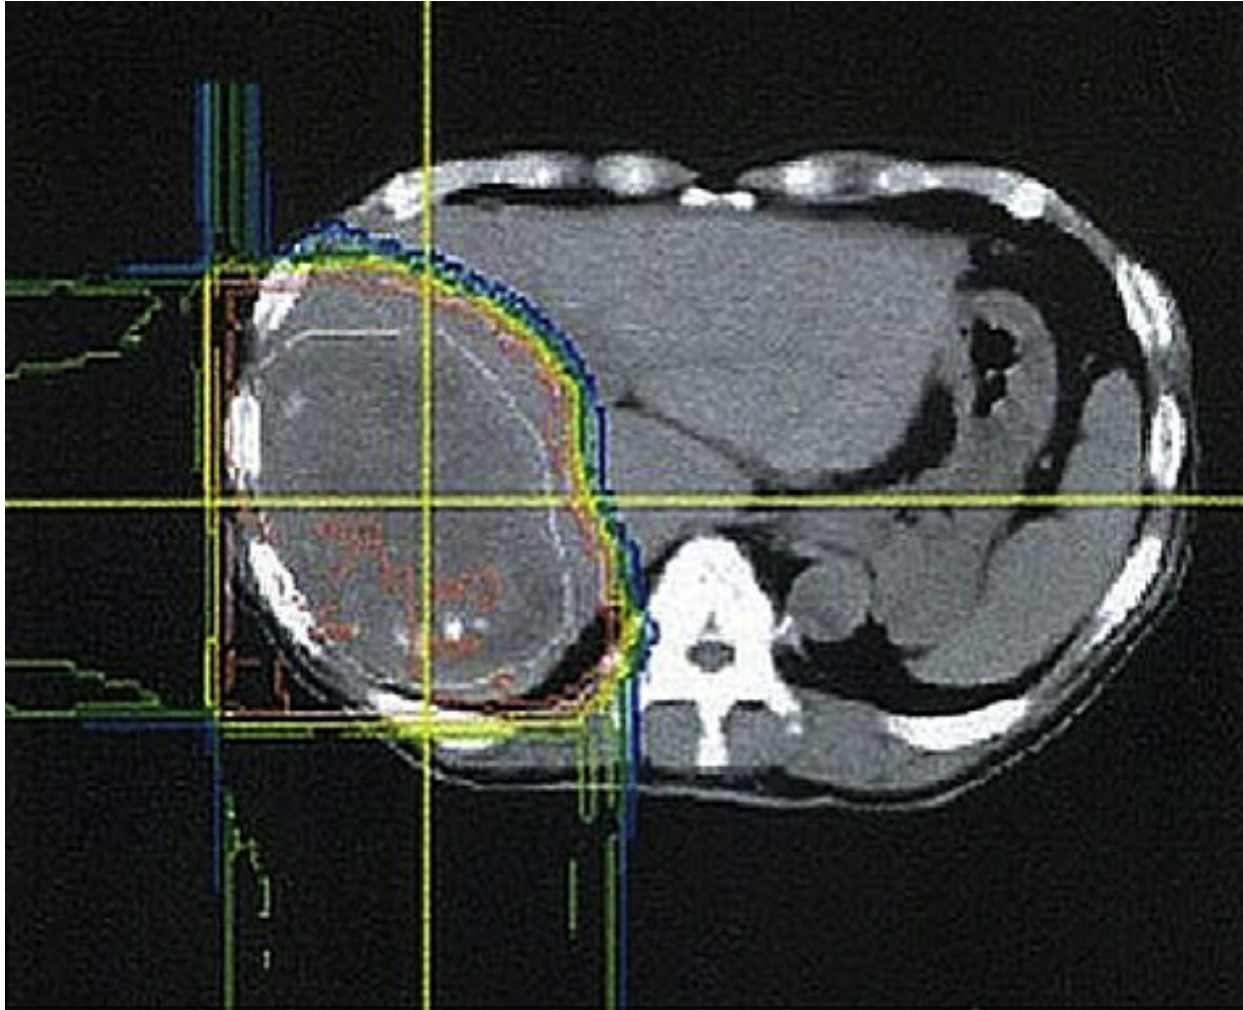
Computed tomography (CT) images of an 81-year-old woman with advanced HCC involving a massive tumor thrombus in the IVC. Images were obtained before PBT (a), during isodose distribution of PBT (b), and 2 months after the completion of PBT (c). PBT demonstrated marked regression of both the main tumor and tumor thrombus (arrows). Isodose distribution is shown using contour lines (red line, 90% isodose; blue line, 10% isodose). HCC, hepatocellular carcinoma; IVC, inferior vena cava; PBT, proton beam therapy.
